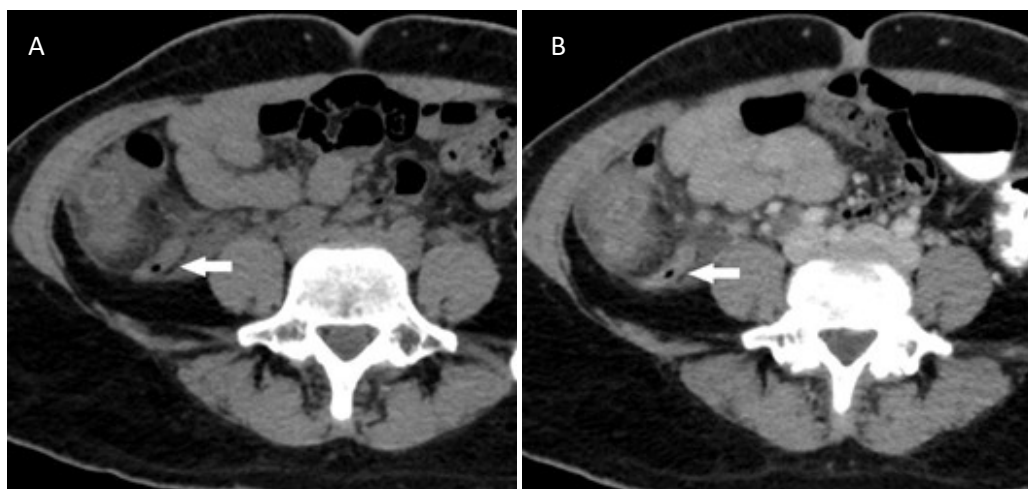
False positive case on both unenhanced and IV-contrast enhanced CT in a 47-year-old woman with acute RLQ pain. On axial CT image of unenhanced CT (A) showed mildly enlarged appendix (arrow), measuring 0.7 cm in diameter with periappendiceal fluid and fat stranding. On axial post contrast enhanced CT image (B) showed mildly enlarged fluid-filled appendix with appendiceal wall hyperenhancement, periappendiceal fluid and fat stranding. The pathological report was mucosal lymphoid hyperplasia of the appendix.
